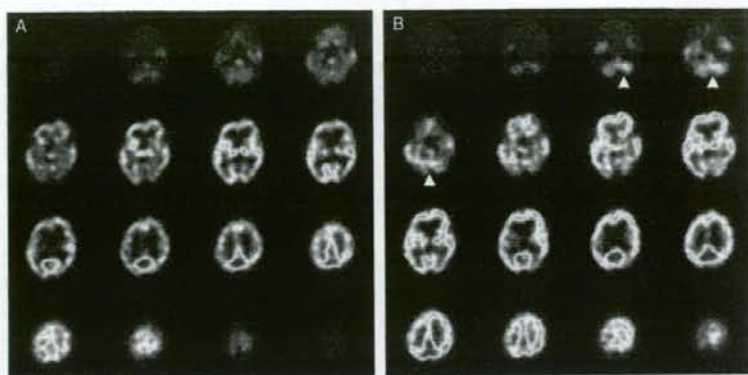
$^{123}\text{I}$ -IMP SPECT of our patient. (A) Before steroid treatment (May, 2006). (B) After steroid treatment (July, 2006).  $^{123}\text{I}$ -IMP SPECT shows hypoperfusion of bilateral cerebellar hemispheres when subacute cerebellar ataxia occurred (A). One month after the beginning of the administration of steroids, cerebellar blood flow was increased (B, arrow heads).
